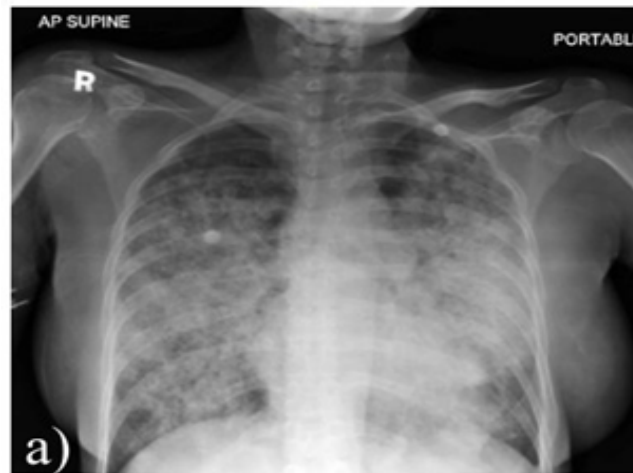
Antero-posterior view of the chest x-ray showing diffuse nodular opacities suggestive of pulmonary haemorrhage
